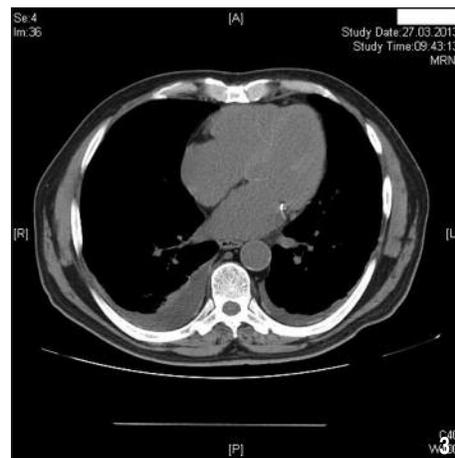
Thoracic CT shows that the diaphragm contours could not be seen clearly on the right side, and reticular infiltration in the lower zone.
